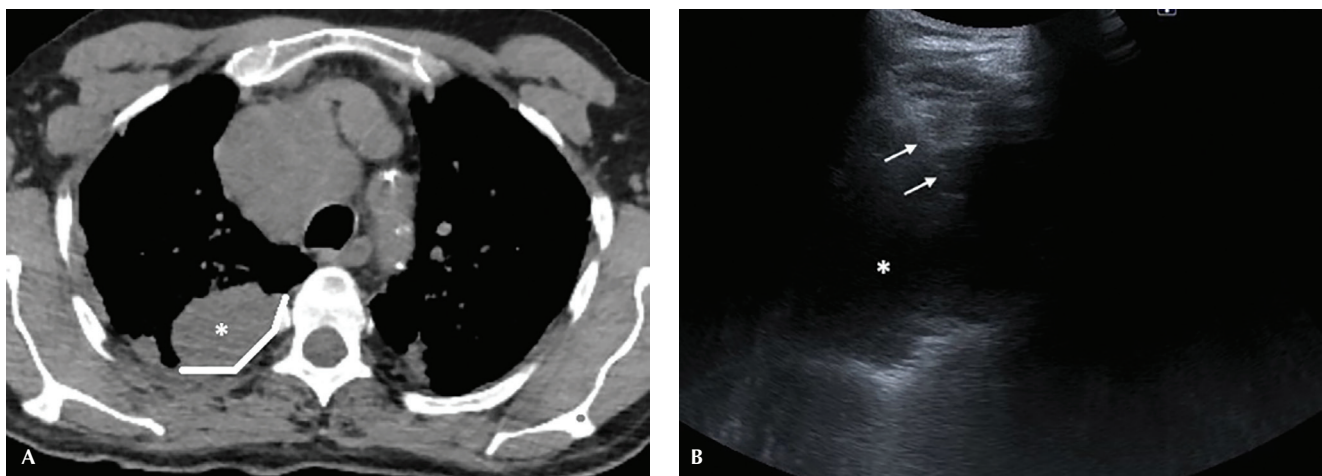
Pleural-contact pulmonary adenocarcinoma in a 65-year-old man. (A) Axial CT image demonstrates a right lower lobe pleural-contact lesion (asterisk); the white line indicates the pleural contact length. (B) Corresponding ultrasound image demonstrates the lesion (asterisk). Arrows indicate the biopsy needle trajectory during ultrasound-guided biopsy
